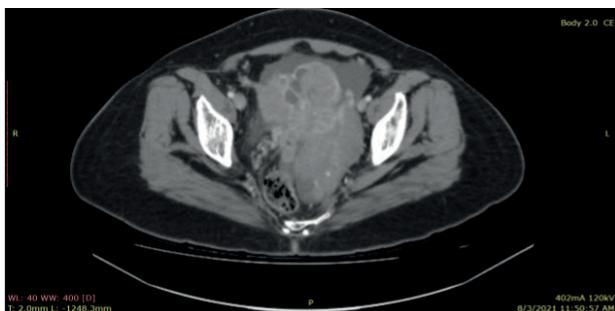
Axial view of computed tomography scan of abdomen post contrast administration, showing a heterogeneously enhancing pelvic mass extending into lower abdomen, likely of adnexal origin. There is mild right hydronephrosis and moderate ascites.
